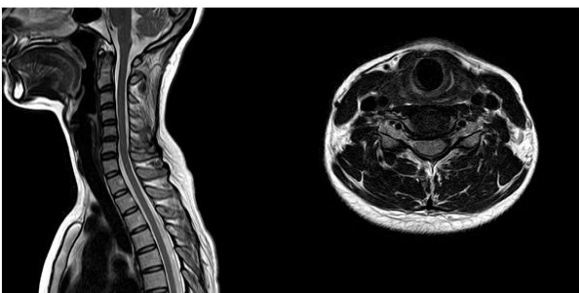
T2-weighted sagittal and T2 weighted axial magnetic resonance images at 11 month follow up
